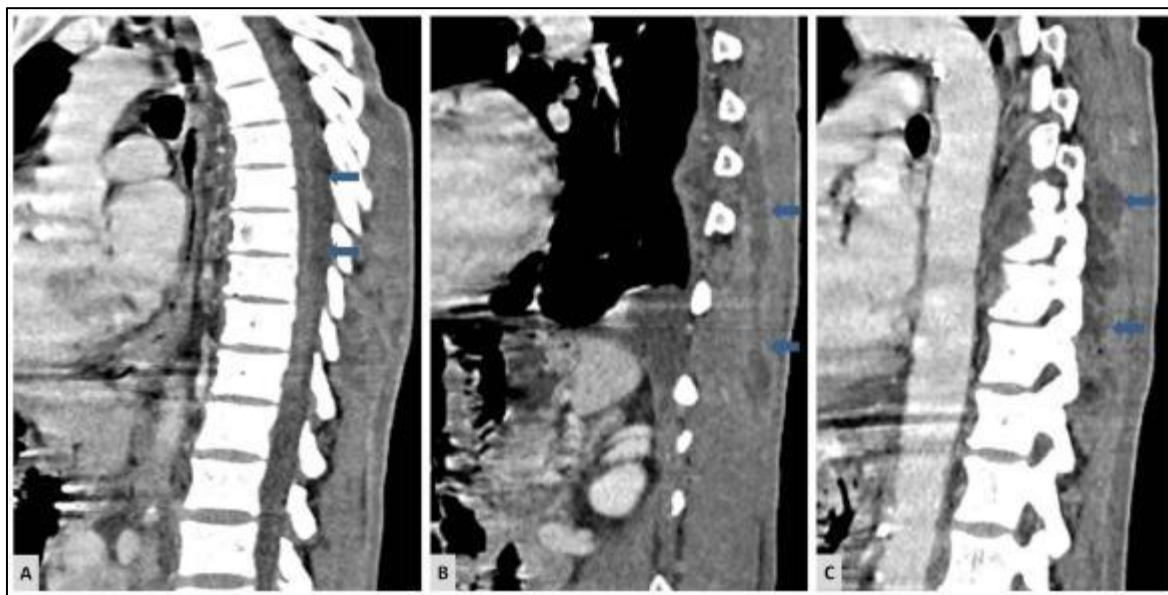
Post-contrast sagittal computed tomography images of the thoracic spine demonstrating a posterior epidural collection extending from T6 to T12, with peripheral enhancement and significant mass effect causing anterior compression of the spinal cord (A). Extension through the intervertebral foramina into the bilateral paraspinous muscles is noted (B, C)
